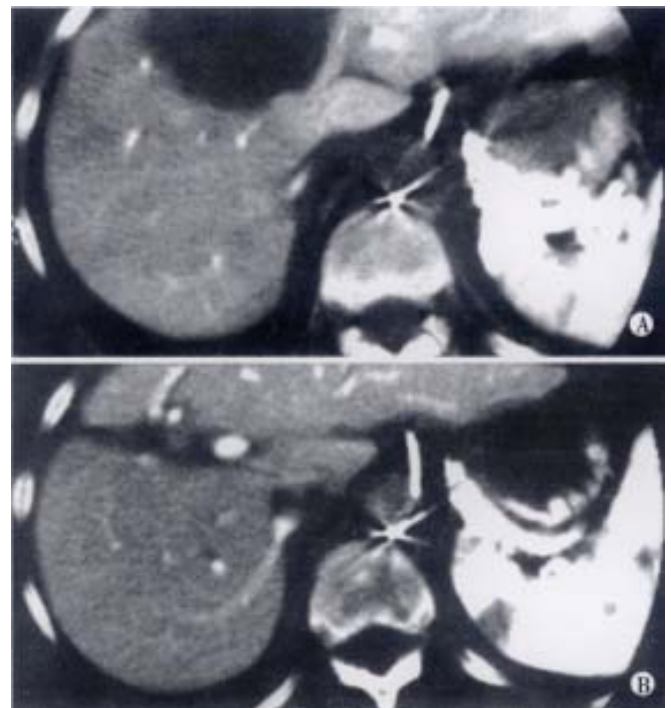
(a) Solitary hepatic metastasis occupying segment 4, 5 and 8, managed by trisegmental resection. (b) CT scan at one year showing hypertrophy of residual left lobe and segments 6/7.
